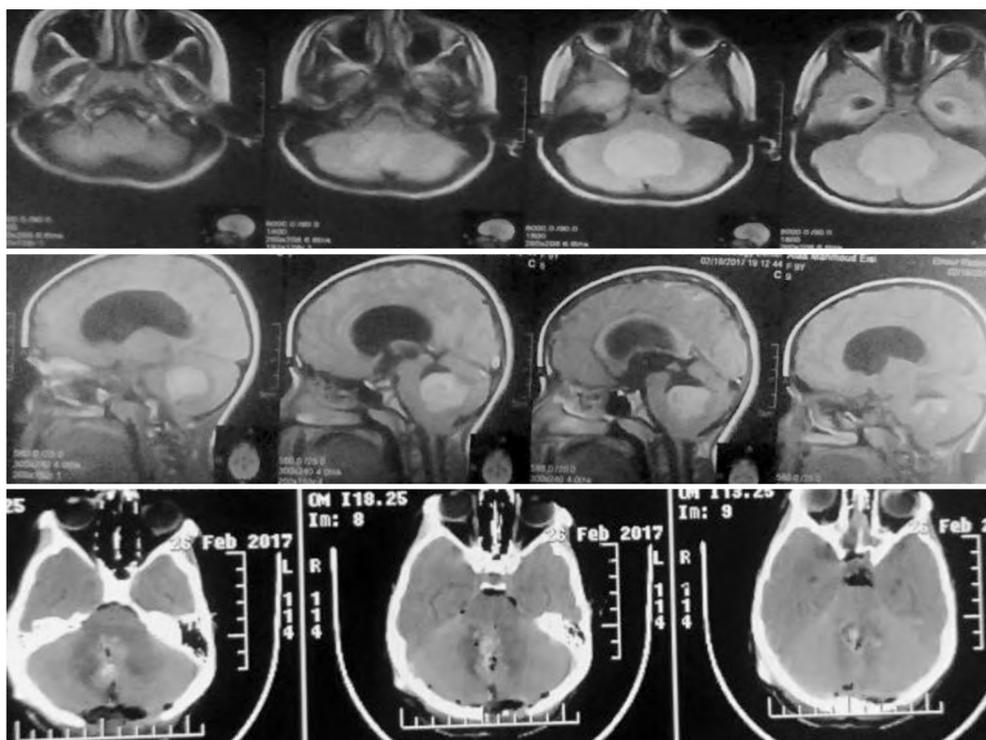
Pre-operative MRI and post-operative C.T scan of 4y child with fourth ventricular ependymoma operated via transversmian route.
